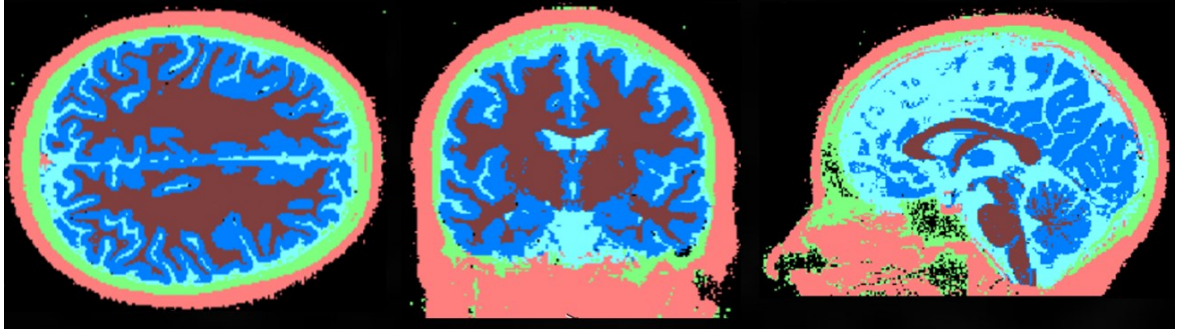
SPM-based segmentation of MRI images in Figure 4.1.
